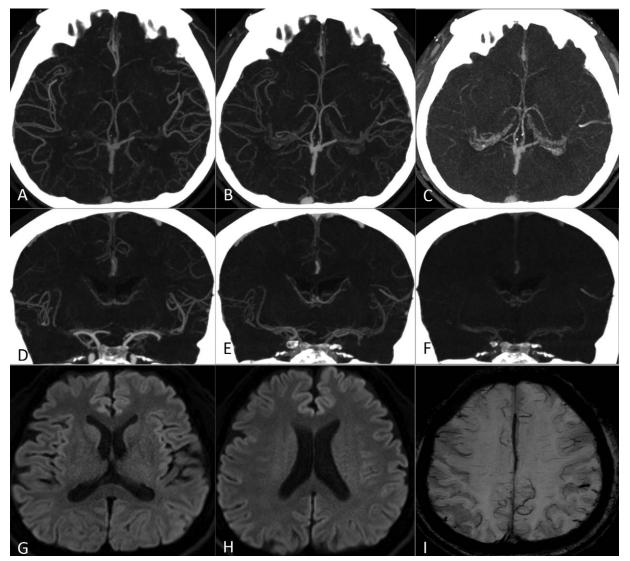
Initial multiphase computed tomography angiography and magnetic resonance imaging (MRI). A–C, Axial images of P1 (late arterial phase), P2 (mid-venous phase), and P3 (late-venous phase). On P3 phase, there is segmental contrast delay at the proximal M3 segment, suggesting proximal M3 occlusion with reversed contrast arrest by collateral flow. D–F, Coronal images of P1, P2, and P3. G–I, Initial MRI. Diffusion-weighted imaging scans (G, H) depict no abnormally high signal intensity; however, migrated embolus is seen at the left far distal middle cerebral artery branch on susceptibility-weighted imaging (I).
